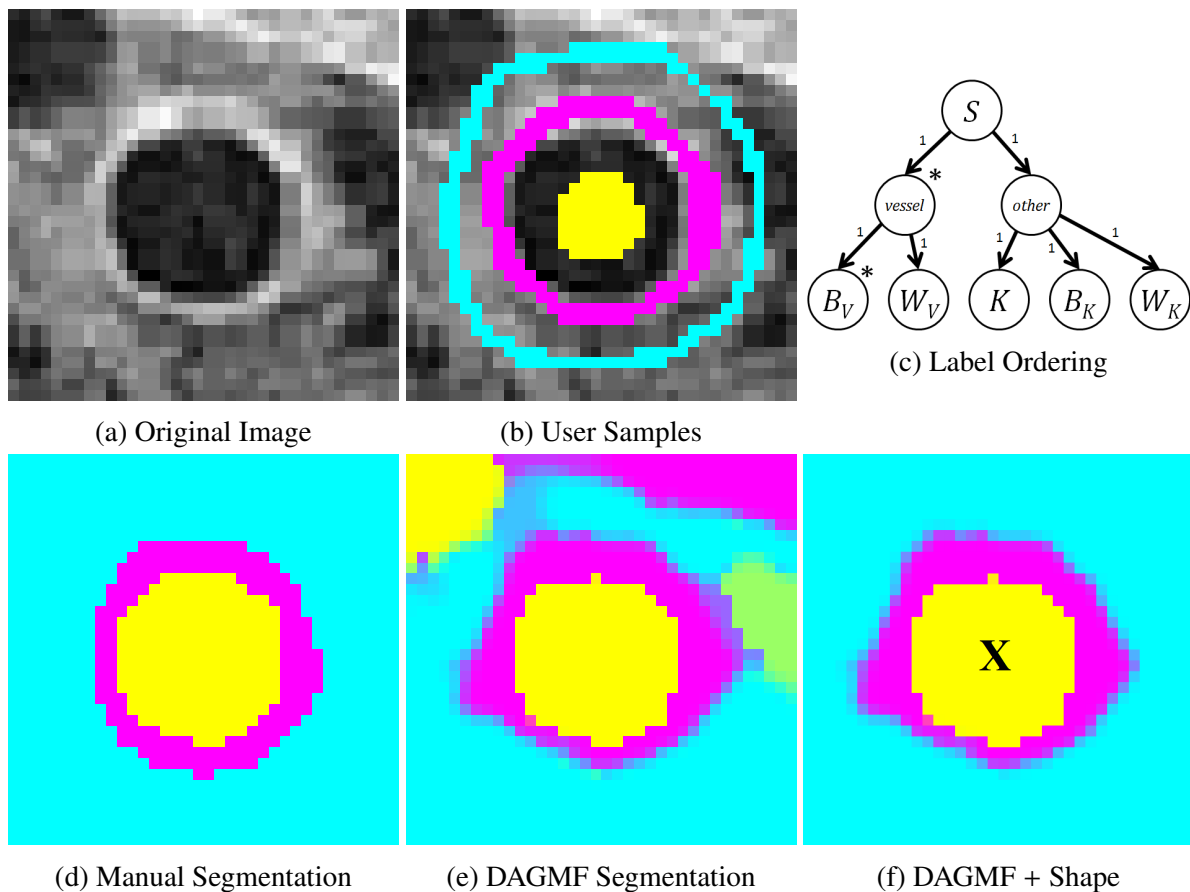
Vessel segmentation in ultrasound with and without shape complexes. The label ordering is given in Figure 5c (\* a simple star convexity constraint is applied to this label) with the vantage point for the shape complex is marked with an 'X'. Similar to Figure 6.2, any overlap between segmentations can cause false colors.
